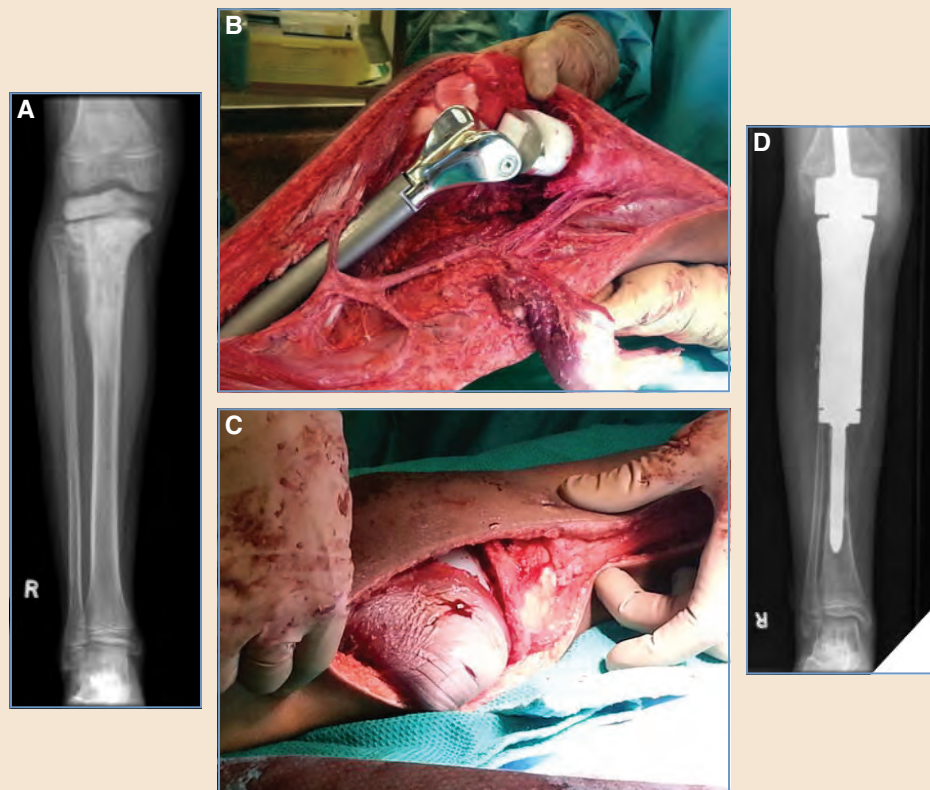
Endoprosthesis reconstruction requires well-vascularized coverage. A, A preoperative radiograph showed a malignant bone tumor of the proximal tibia, necessitating joint removal. B, With the endoprosthesis in place, the gastrocnemius muscle was mobilized and transposed to cover the prosthetic device. C, The muscle flap was transferred and sutured in place. D, A postoperative radiograph shows the endoprosthesis well integrated into the femur proximally and the tibia distally.
